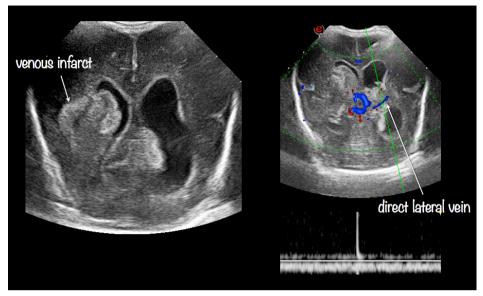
Right direct lateral vein infarction: observe the unaffected left vein in Doppler imaging (arrow).
